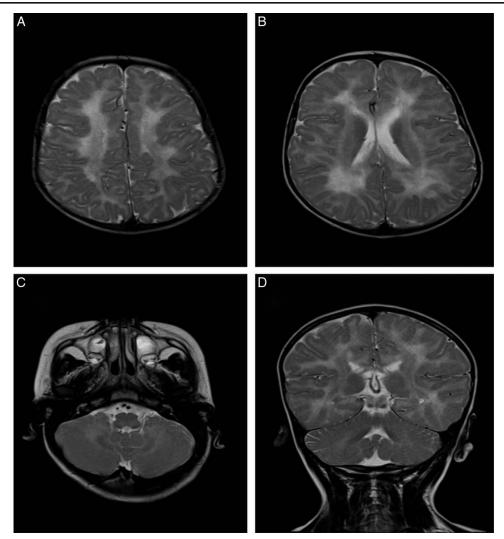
MRI without contrast of the brain with T2 bilateral hyperintense areas symmetrically in the centrum semiovale (A), periventricular white matter (B), cerebellum white matter (C). Figure 2-D. Coronal slice shows the affected areas in the white matter.
